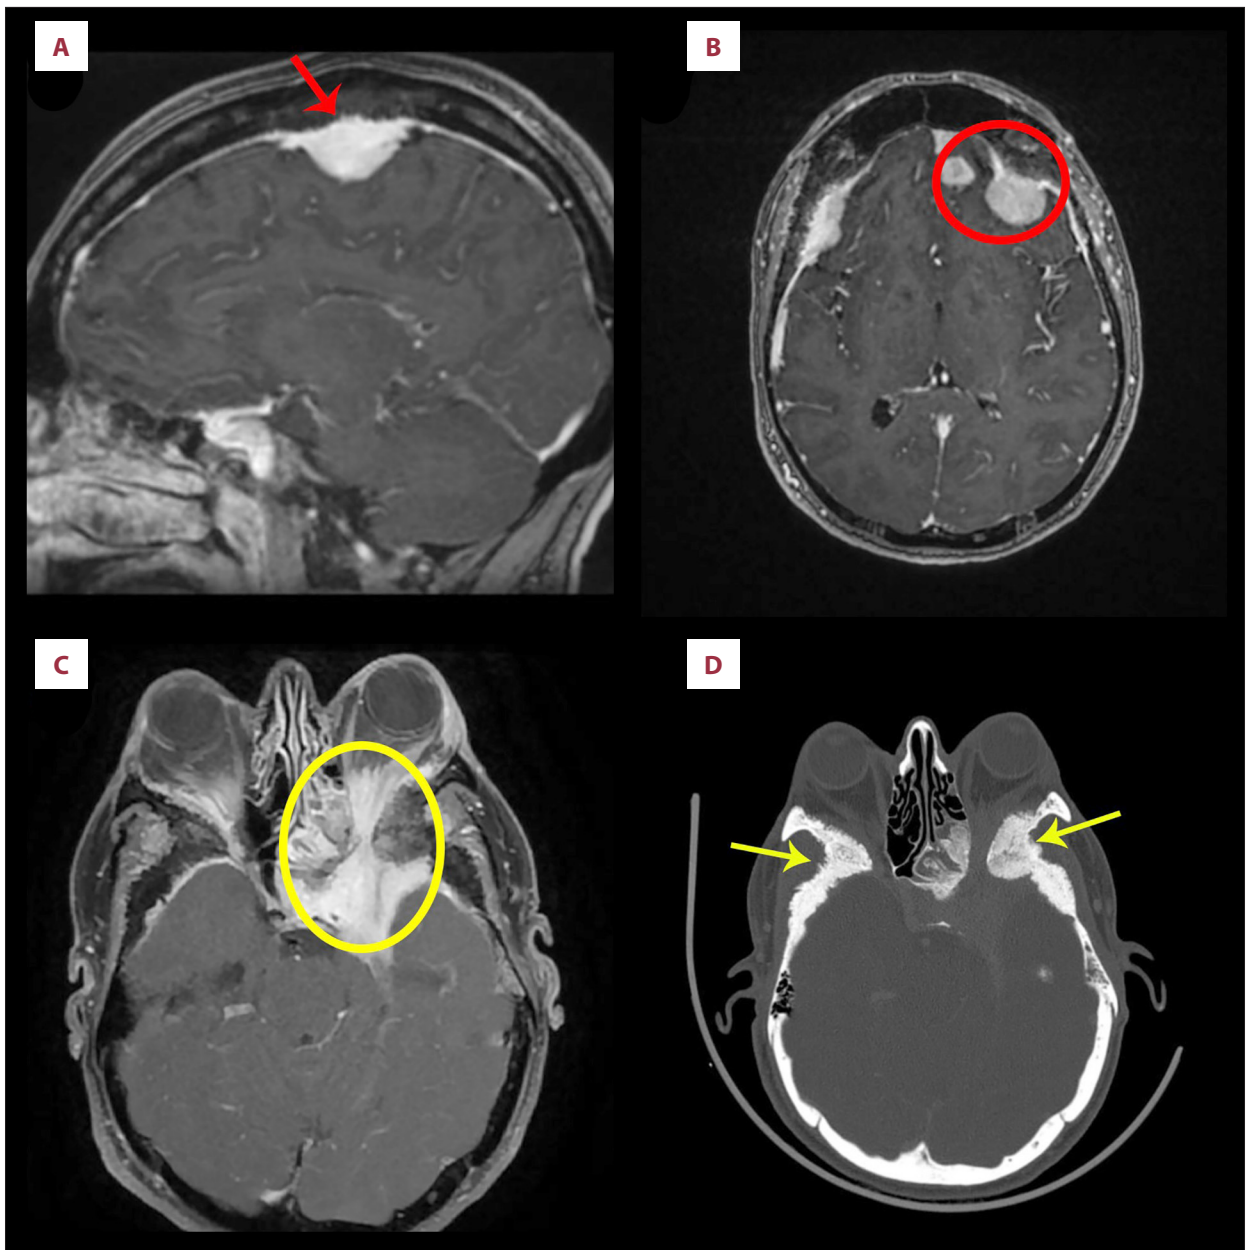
Imaging findings of the patient. (A) Sagittal T1-weighted post-gadolinium magnetic resonance imaging demonstrating a homogeneously enhancing parasagittal extra-axial meningioma with invasion of the superior sagittal sinus (red arrow). (B) Axial T1-weighted post-gadolinium MRI showing multiple left frontal convexity meningiomas adjacent to the falx (red circle). (C) Axial T1-weighted post-gadolinium magnetic resonance imaging demonstrating a meningiomatous lesion involving the left cavernous sinus with extension into the ipsilateral orbit through the optic canal (yellow circle). (D) Axial computed tomography bone window demonstrating marked hyperostotic and sclerotic changes of the sphenoid bone with a spiculated pattern (yellow arrows).
